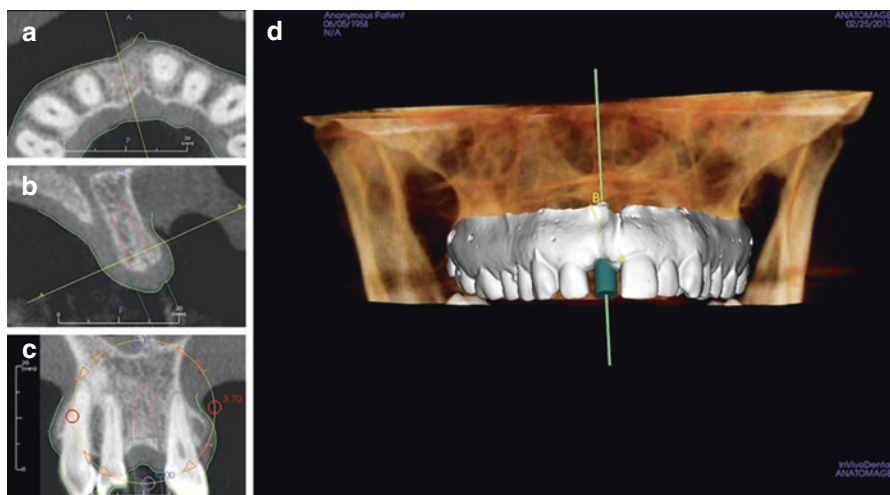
In silico implant placement at the area of missing tooth #8. (a–c) Axial, sagittal, and cross-sectional views showing the outline of the implant superimposed on the alveolar ridge. (d) 3D view showing the orientation of virtual implant #8 relative to the adjacent teeth and maxillofacial structures. Note the fusion of optical scan data with the CBCT volume. (Images courtesy of Anatomage, Inc.)
